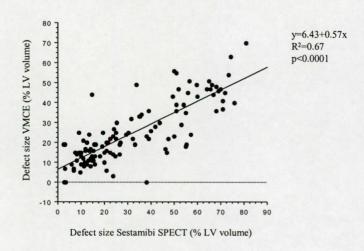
Simple regression analysis of initial defect size measured by Sestamibi single photon emission computer tomography (SPECT) and venous myocardial contrast echocardiography (VMCE).
